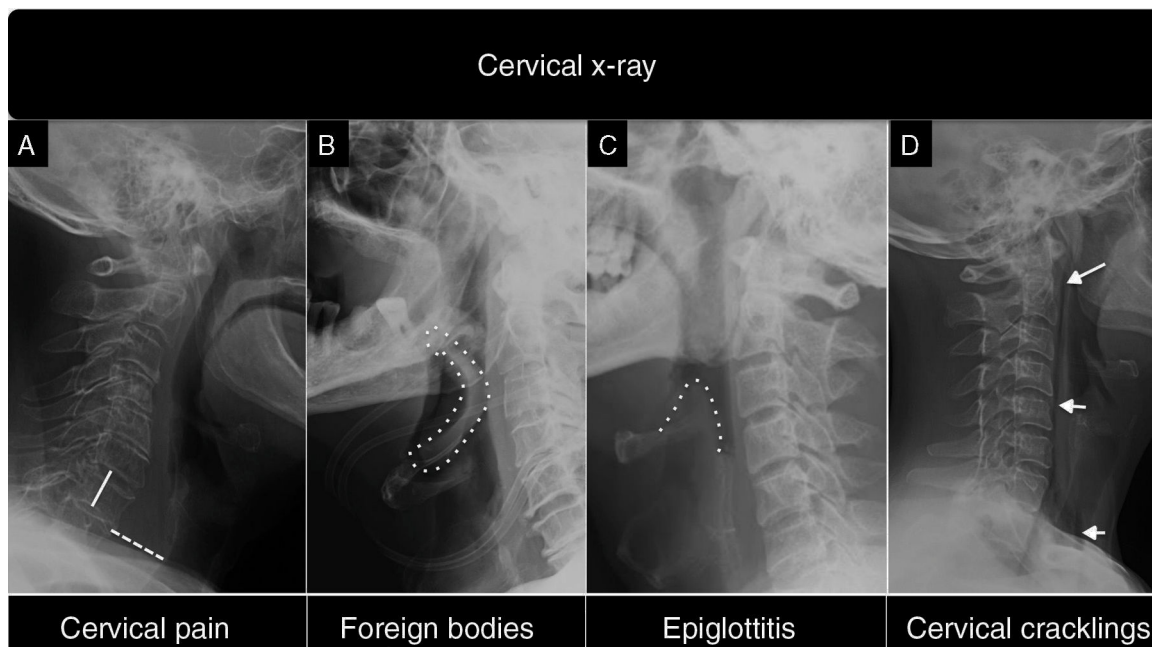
Indications of a simple X-ray. (A) Patient at admission presenting with cervical pain. There is an increase of prevertebral soft parts. The prevertebral diameter – dotted line – is greater than the height of the vertebral body – continuous line. This led to indicating a cervical MRI where it was possible to see an abscess secondary to spondylodiscitis. (B) Patient with dementia who abruptly refers dysphagia. The X-ray revealed the presence of a foreign body: "his dentures" (dotted line). (C) 18-month-old child with epiglottitis. The "thumb" image characteristic of this process can be observed (dotted line). (D) Young woman presenting with dyspnea and dysphagia of abrupt occurrence; cervical cracklings in clinical examination. Findings were secondary to spontaneous cervical emphysema (arrows).
